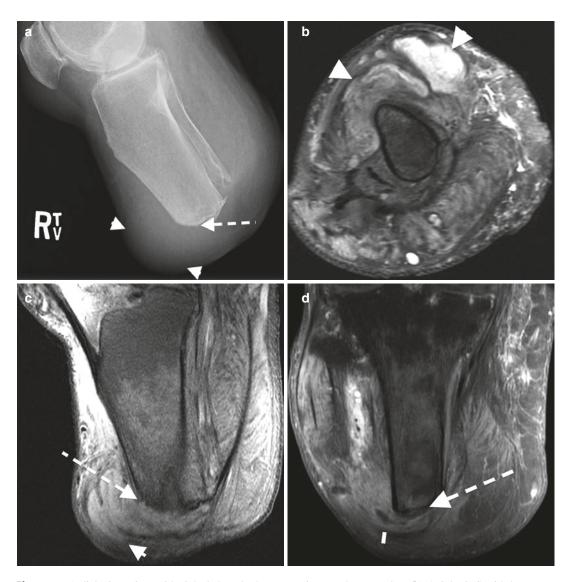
A diabetic patient with right below-the-knee amputation presenting with soft tissue swelling, erythema, and fever. (a) Lateral radiograph stump demonstrates distal soft tissue swelling of increased density (*arrowheads*) when compared to adjacent soft tissue suggesting collection and underlying cortical irregularity, subtle periosteal reaction (*dashed arrow*), and adjacent mixed sclerosis and lucency in keeping with osteomyelitis. MRI of the same
